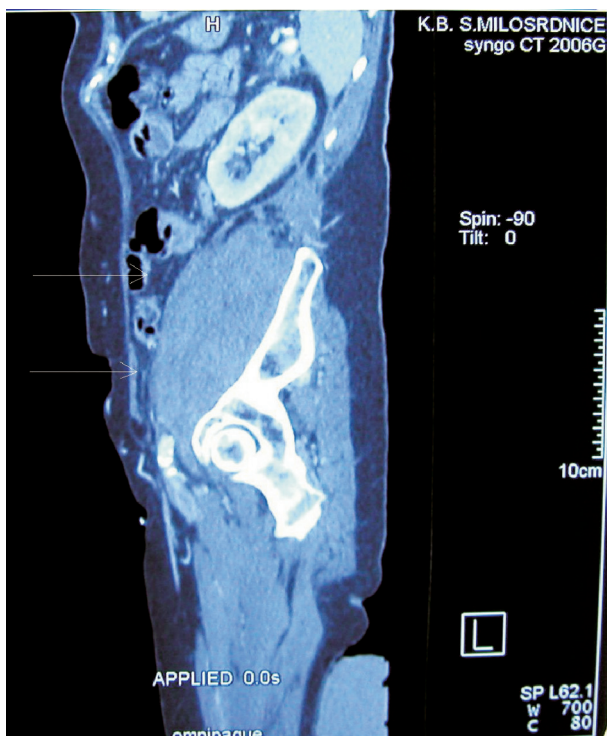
Sagittal CT scan showing expansion of the retroperitoneal hematoma to the left inguinal region.
